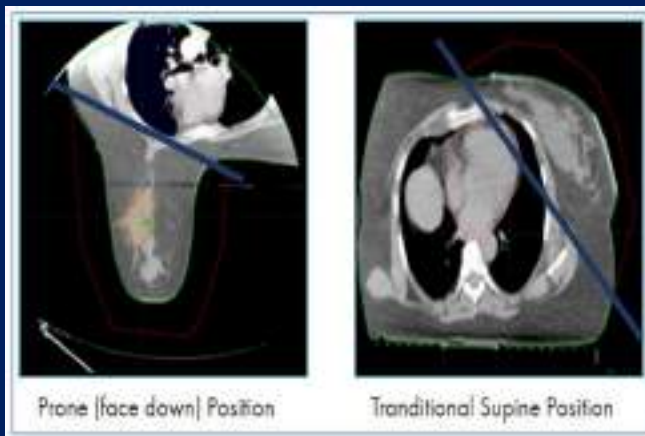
CT scan showing pushing away of heart and lungs from the treatment fields in prone position
